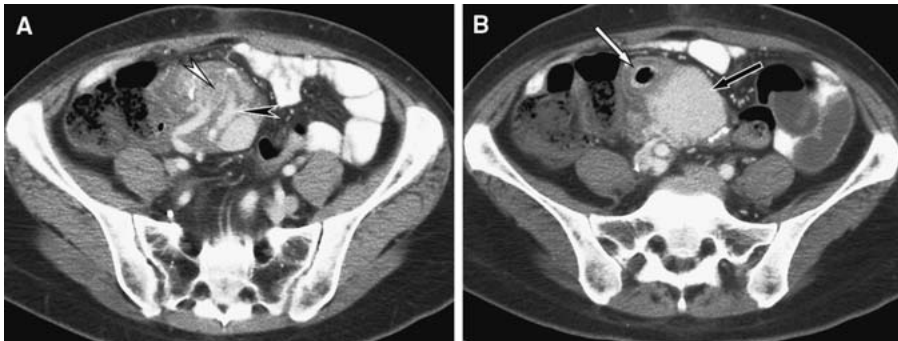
A Axial CT in a 40-year-old female shows a thrombosed donor superior mesenteric artery within the transplant (*white arrowhead*). This is finding is often seen intraoperatively by surgeons and does not affect graft survival. Note the normal donor portal vein (*black arrowhead*). B The pancreatic transplant enhances well (*black arrow*). Note the donor duodenum (*white arrow*).
